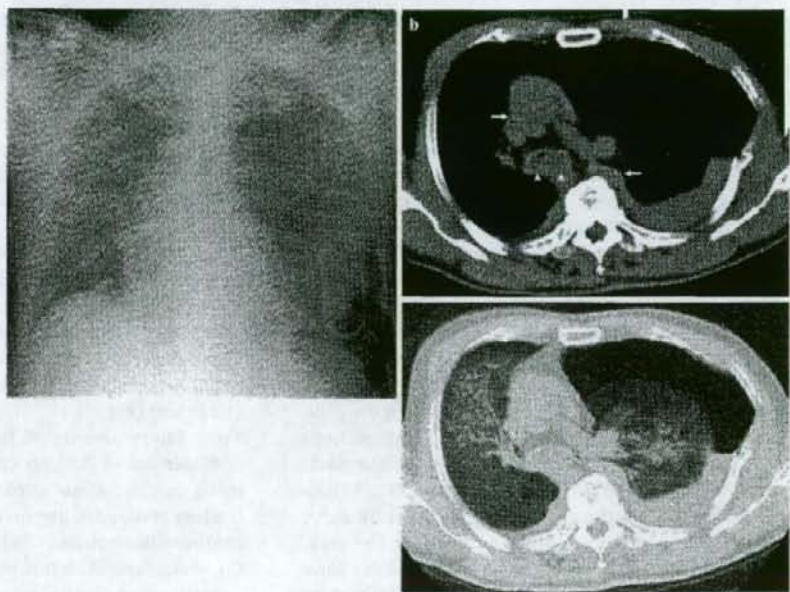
Grade C injury of the thorax in a 69-year-old man whose motorcycle collided with a truck (patient 78 in Table 1). There was no response to CPR. a Chest radiograph at the time of resuscitation shows a bilateral hazy increase in opacity, left pneumothorax, and mediastinal deviation to the right. b PMCT was performed 40 min after confirmation of death.
